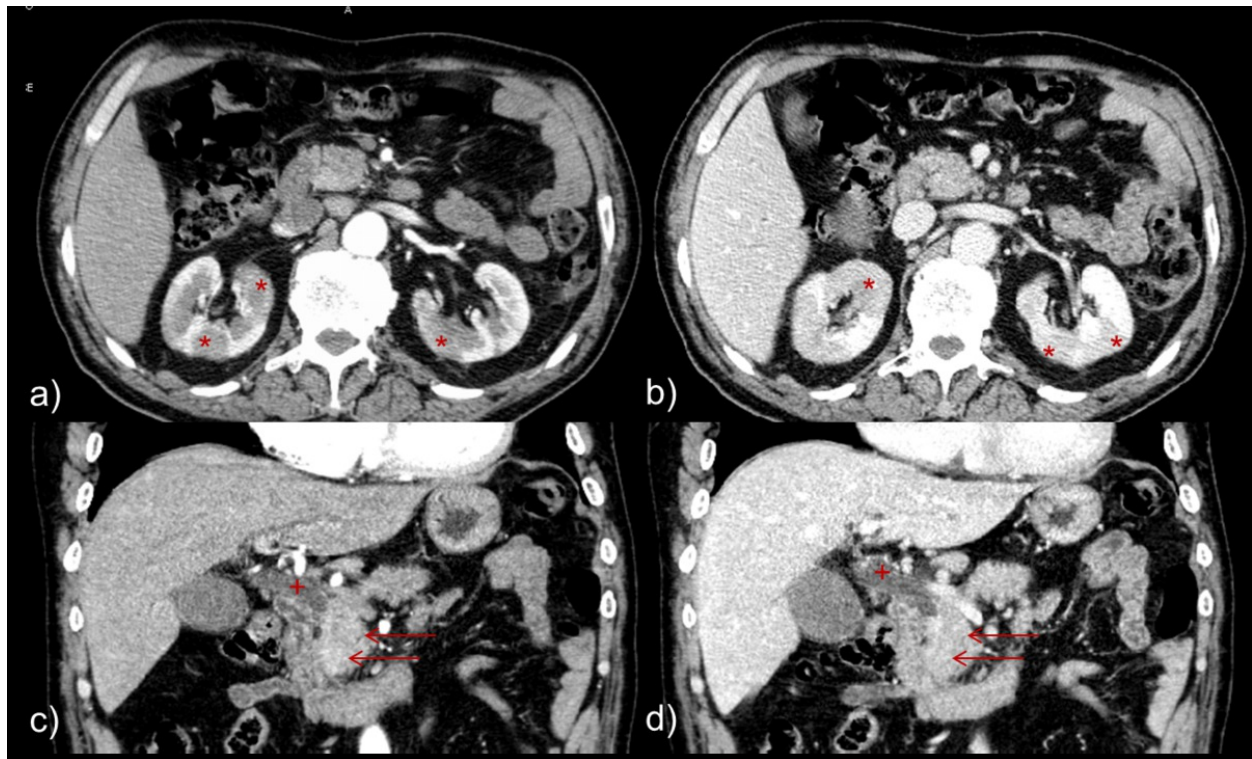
Enhanced axial CT images in pancreatic a) and portal venous phase b), and enhanced coronal CT images in pancreatic c) and portal venous phase d) of a patient with a focal swelling at the pancreatic head, enhancing similarly with the remaining pancreatic parenchyma (arrows). This focal swelling was responsible for slight dilatation of the common bile duct (+), pancreatic parenchymal atrophy or main pancreatic duct dilatation was not seen. The presence of peripheral and wedge-shaped renal cortical nodules that were hypovascular in pancreatic phase with slight enhancement in portal venous phase (*) were consistent with interstitial nephritis, thus favoring the diagnosis of focal autoimmune pancreatitis. About 1/3 of the patients with autoimmune pancreatitis present interstitial nephritis also occurs.
